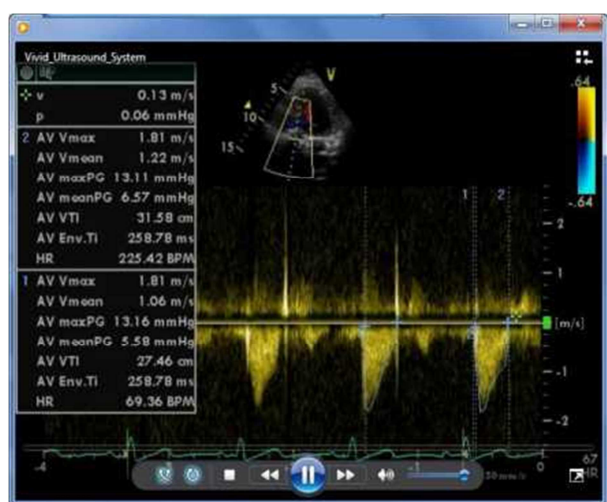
Doppler echocardiography after transcatheter aortic valve implantation showed peak pressure gradient: 13.1 mean pressure gradients: 6.5 mmHg
